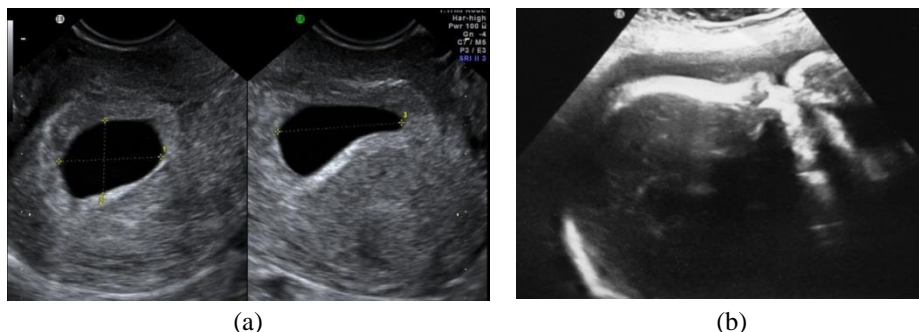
8: Examples of 2D B-mode ultrasound images (a) US in Sagittal and Transvers plane for GS (b) US image in Sagittal plane of 37 weeks of fetal
